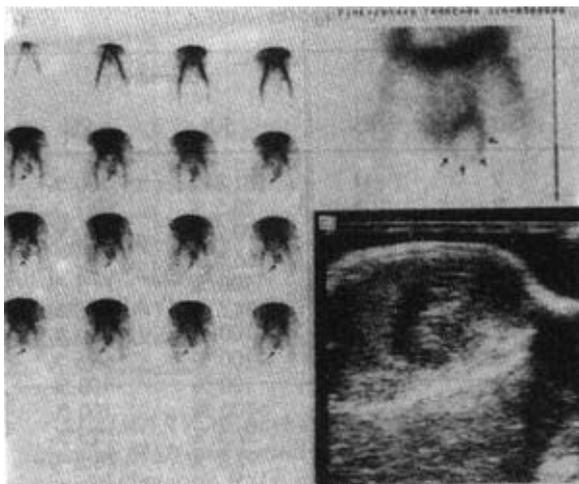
Abscess. Increased perfusion in radionuclide angiography (a), bull's eye appearance in static images (b), testicular hypertrophy, echo heterogeneity with cystic necrosis in scrotal ultrasonography (c).
